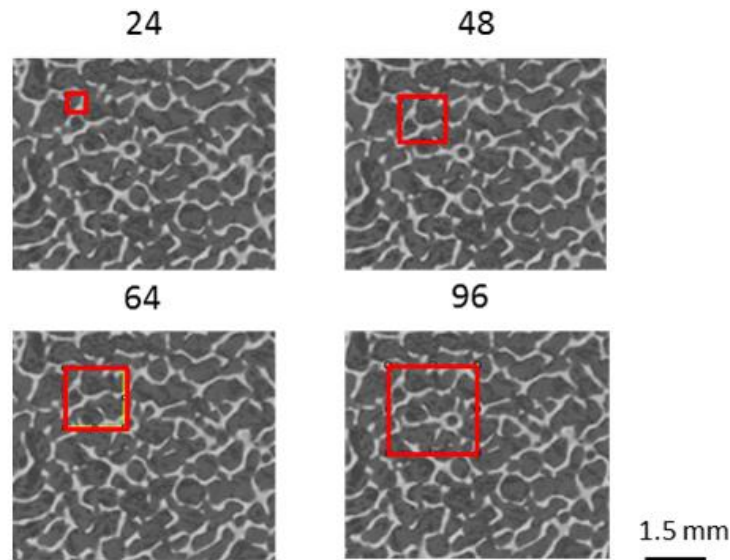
CT slices with sub-volumes of different sizes in relation to features of trabecular bone.
